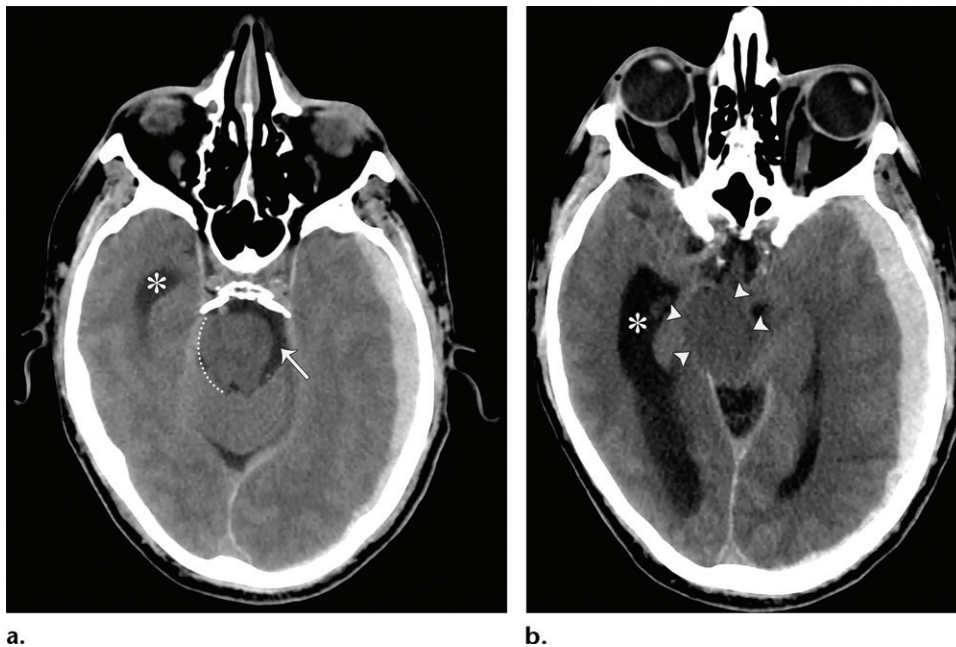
DTH in a 38-year-old man with an acute head injury and left subdural hematoma. There is right shift and mild rotation of the brainstem. (a) Axial nonenhanced CT image shows widening of the left basal cistern (arrow) and effacement of the right basal cistern (dashed line), as well as dilatation of the temporal horn of the right lateral ventricle (*). (b) CT image shows compression and rotation of the midbrain, which appears elongated (arrowheads). There is complete obliteration of the perimesencephalic cisterns. Note the widening of the opposite ventricular atrium and temporal horn (*).
